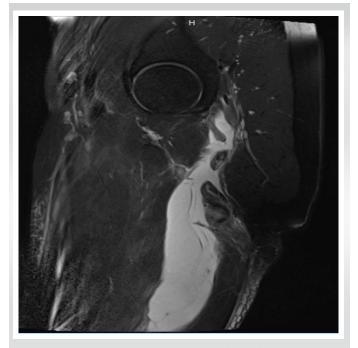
Sagittal T2 fat-suppressed MRI of the left hip showing the proximal hamstring tendon rupture with 8 cm of tendon retraction and large surrounding hematoma.
